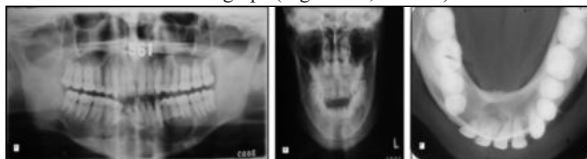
A and B. Radiographs shows KCOT at the time of recurrence. A well-defined multilocular radiolucency in the periapical region of 36 to 44 with C. Buccal cortical plate expansion in 34, 35 and 45, 46 region.
